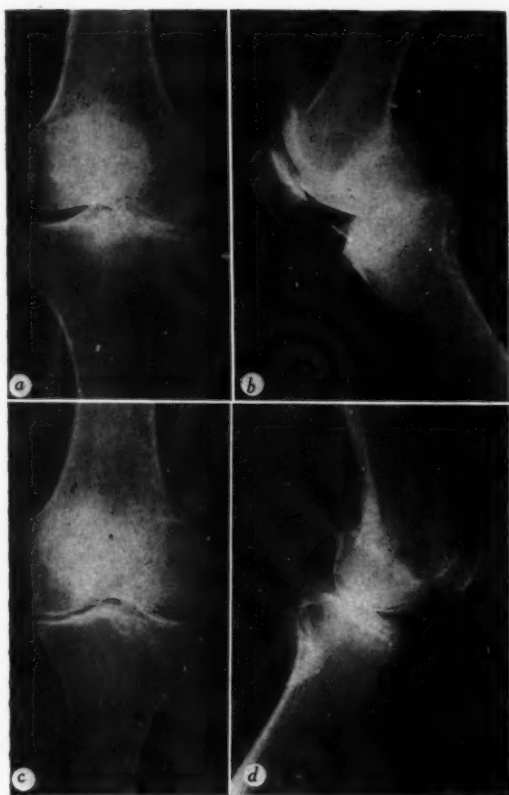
a*, Anteroposterior and, *b*, lateral roentgenograms of right knee; *c*, anteroposterior and, *d*, lateral roentgenograms of left knee. Patient was fifty-six years of age and had bilateral osteoarthritis.
